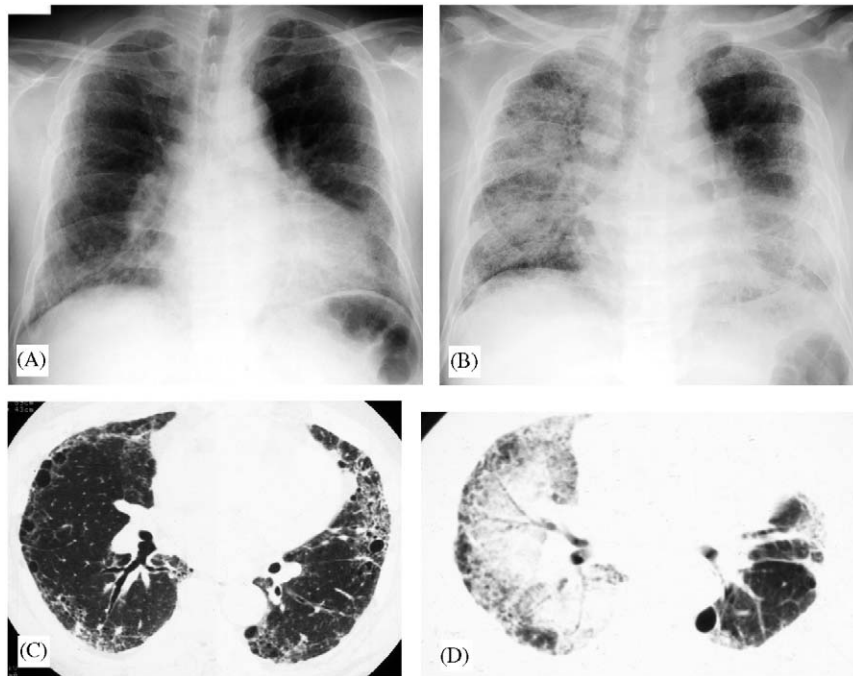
A 60-year-old man with IPF who underwent left-sided surgical biopsy. (A) Chest radiograph before surgical lung biopsy (SLB) shows predominantly peripheral, bilateral lower zone reticular shadows. (B) Chest radiograph obtained 5 days after SLB shows bilateral ground glass changes and consolidation, predominantly in the nonoperated lung. (C) CT scan of the lower lobes before surgical lung biopsy (SLB) shows peripheral bilateral reticular change. (D) CT scan of the lower lobes obtained 5 days after SLB shows enhanced ground glass change and consolidation affecting the nonoperated lung.
